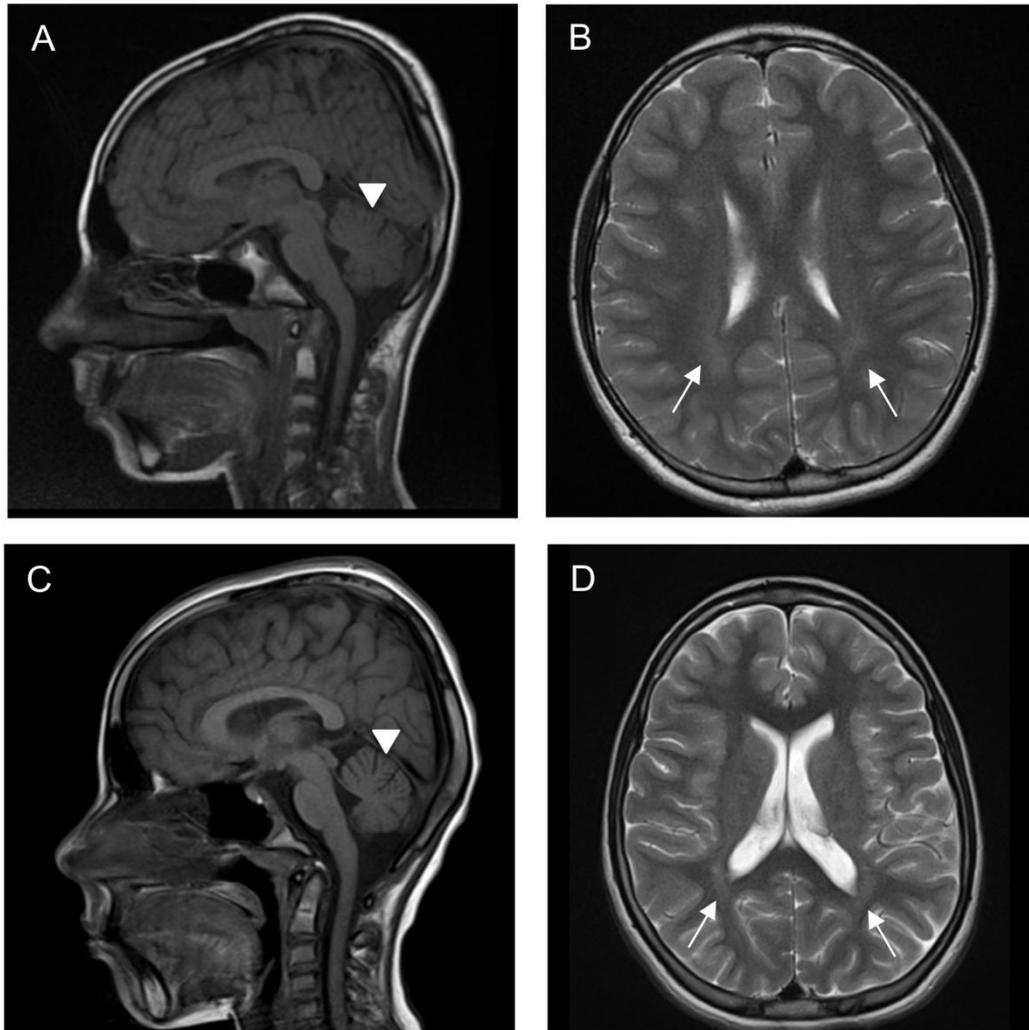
Brain MRI scans of affected subjects. Thalamic atrophy (white arrows) and mild vermian cerebellar atrophy (arrowheads) of subjects IV:1 (*A*) and IV:2 (*C*) in axial T1 weighted MRI sequences. Bilateral periventricular posterior dominant hyperintensities (white arrows) of subjects IV:1 (*B*) and IV:2 (*D*) in axial T2 weighted MRI sequences.
